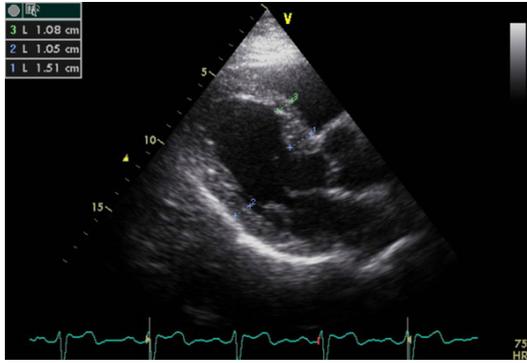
Parasternal long-axis echocardiography shows a predominant regional LV septal base during end-diastole in a hypertensive patient with basal septal hypertrophy.
